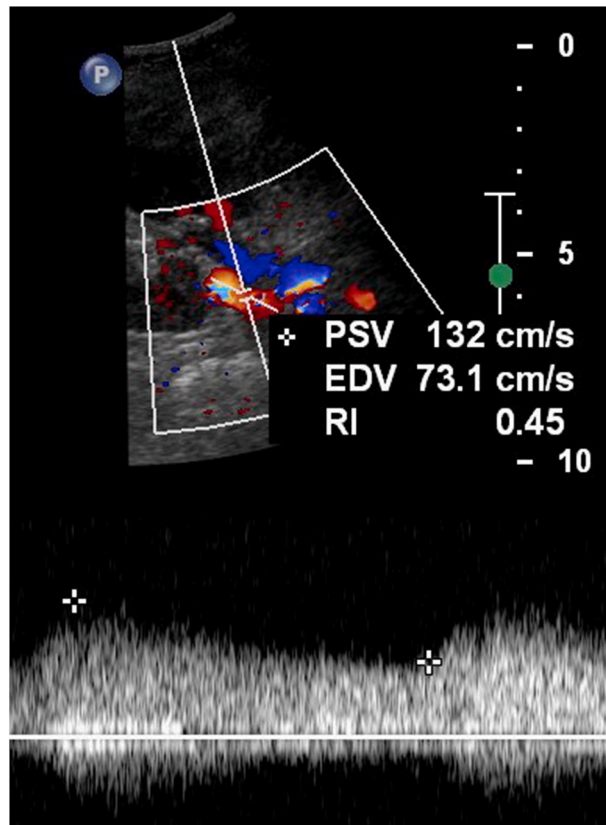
Doppler ultrasonography of the graft renal artery showing a dampened, low-resistance waveform. The renal arterial resistive index (RI) was reduced to 0.45.
